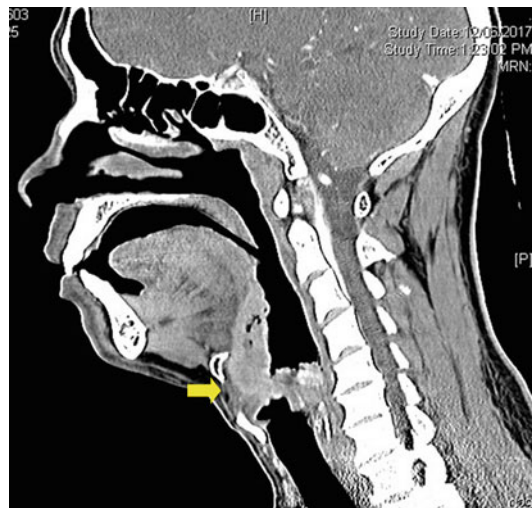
Contrast-enhanced CT neck sagittal image showing a base of tongue tumor infiltrating into the pre-epiglottic space (yellow arrow)
